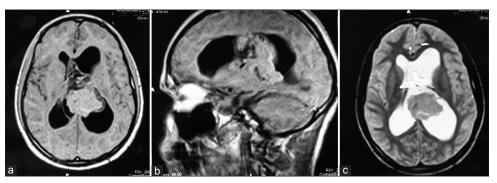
Contrast-enhanced magnetic resonance imaging showing tumor in (a) T1-weighted (axial view; postcontrast), (b) T1-weighted (sagittal view), (c) T2-weighted (axial view) images
